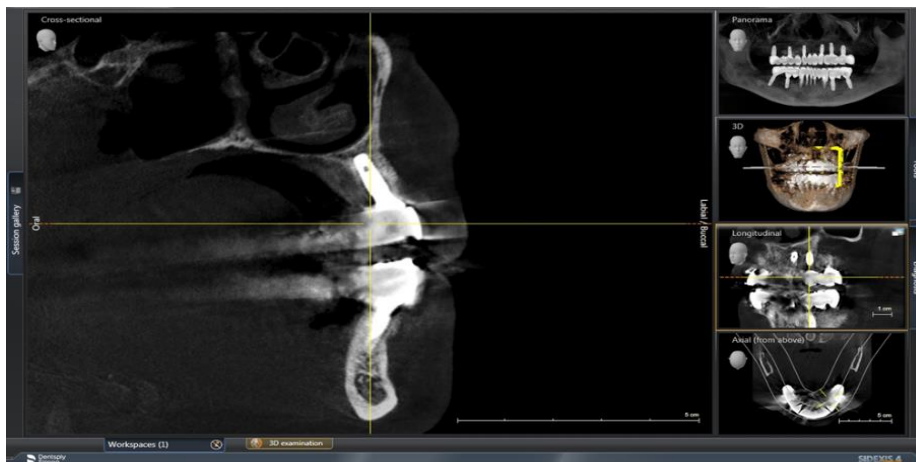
Final CBCT Scan showing the bone thickness on 14 and 34.
